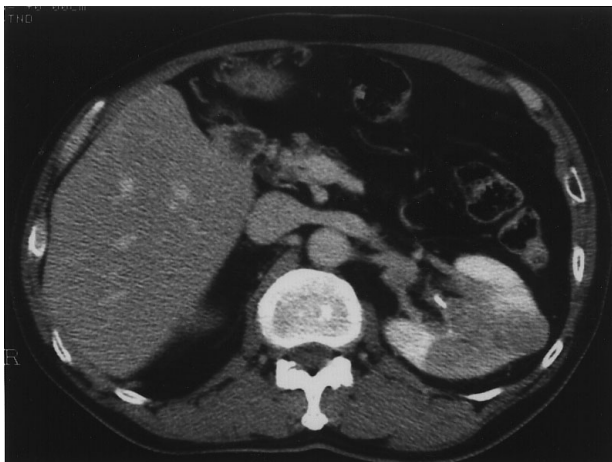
Contrast-enhanced CT scan showed a tumor in the cortex and the medulla of the left kidney.
